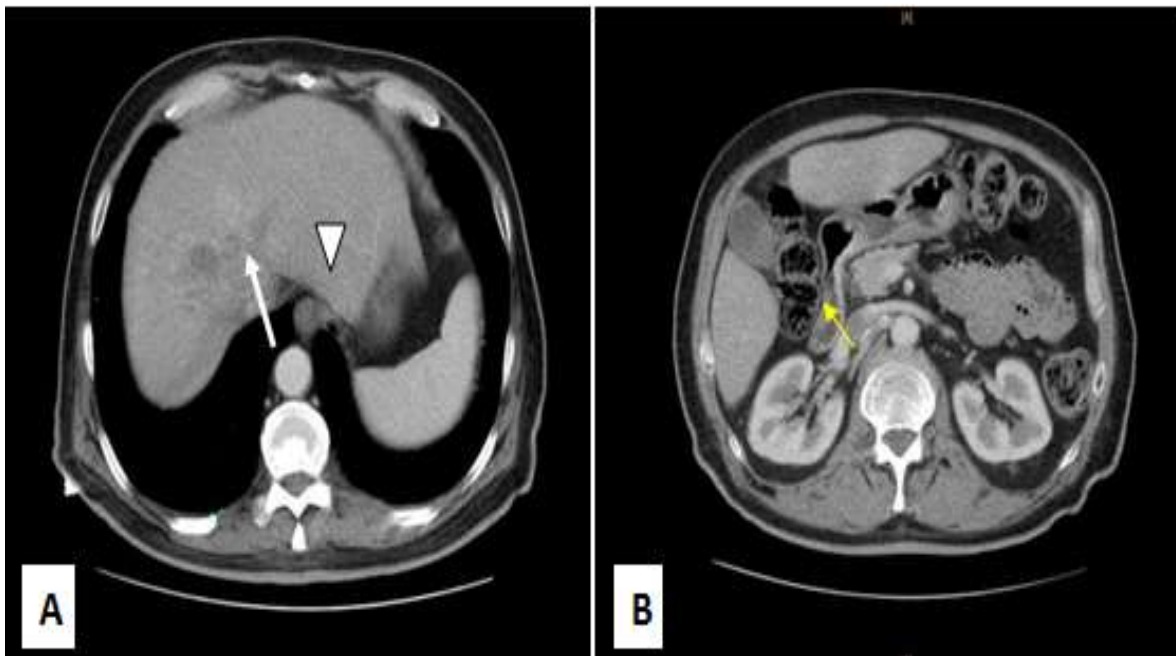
CT scan of abdomen. Axial view. A: The arrow indicates an irregular hypodense hepatic mass with invasion of the inferior vena cava (arrowhead). B: Thrombosis of the right kidney vein was also noted.
